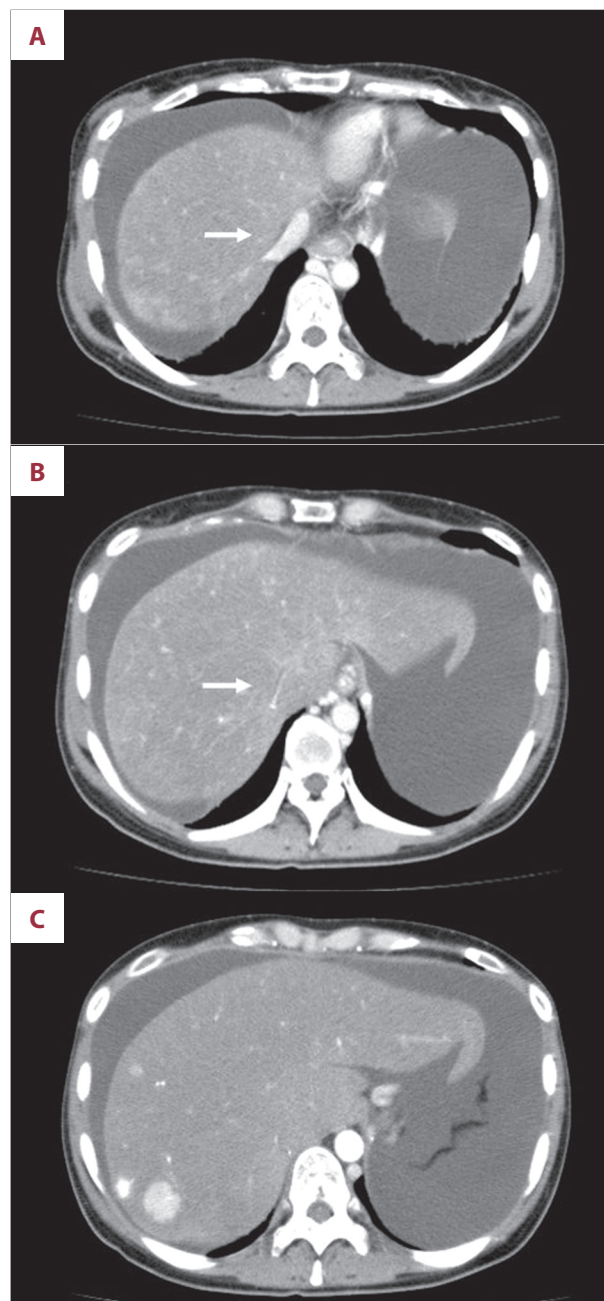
Computed tomography (CT) of the patient (case 1) revealed narrowing of the inferior vena cava (IVC) and massive ascites (A, B). An early enhanced nodule was seen in S8 (C).
